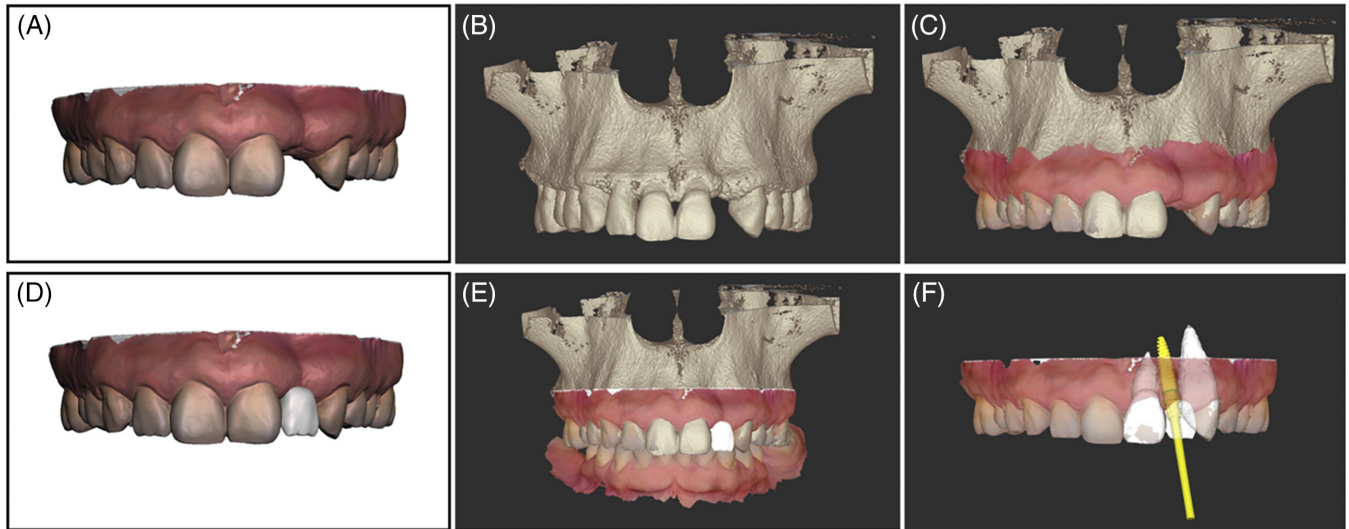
Registration process (superimposition) of digital tooth arrangement for virtual implant planning. (A) Baseline IOs (PLY); (B) Baseline CBCT scan render (DICOM); (C) Registration of A + B; (D) Digital tooth arrangement performed on (A); (E) Registration of D + C to include intended restoration design—note that lower IOs is also registered to assess occlusion; (F) Virtual implant planning based on (E)—note that adjacent teeth segmentation provides additional visual information of adjacent teeth roots position.
